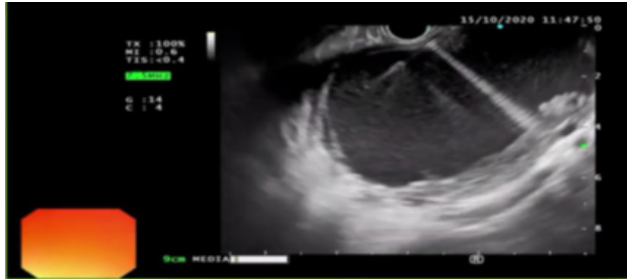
EUS-guided FNA of pancreatic pseudocyst. EUS, endoscopic ultrasound.
